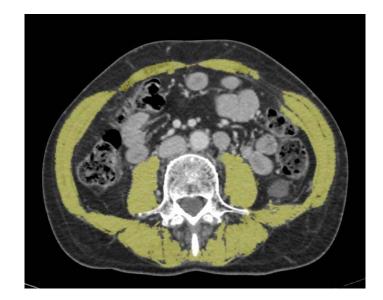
Total abdominal muscle area measurement in CT Scan.
